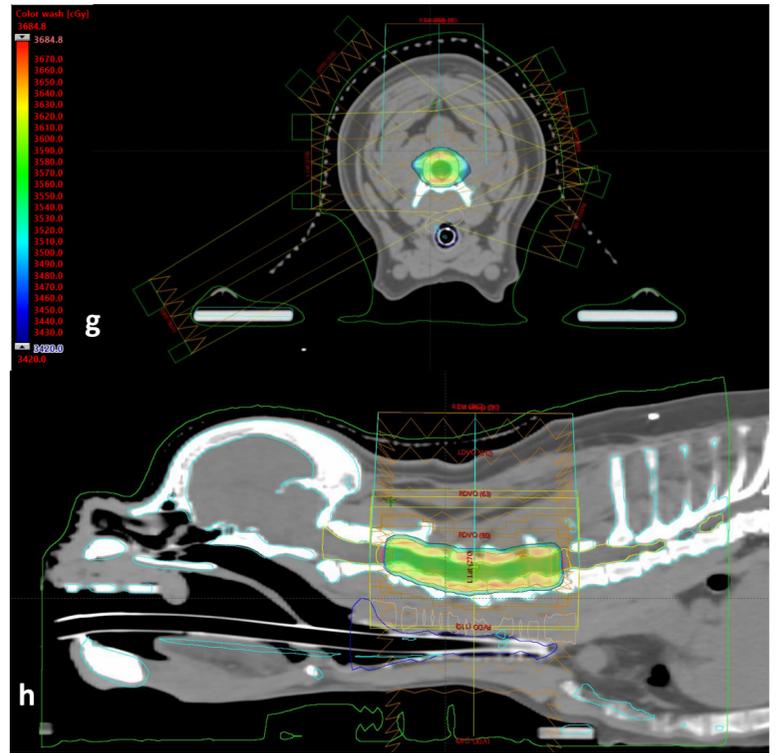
Representative transverse (g) and sagittal (h) CT images of the IMRT plan, which was created using Varian's Eclipse™ planning software. Colour wash shows the areas which received at least 95% of the prescribed dose (36Gy).
